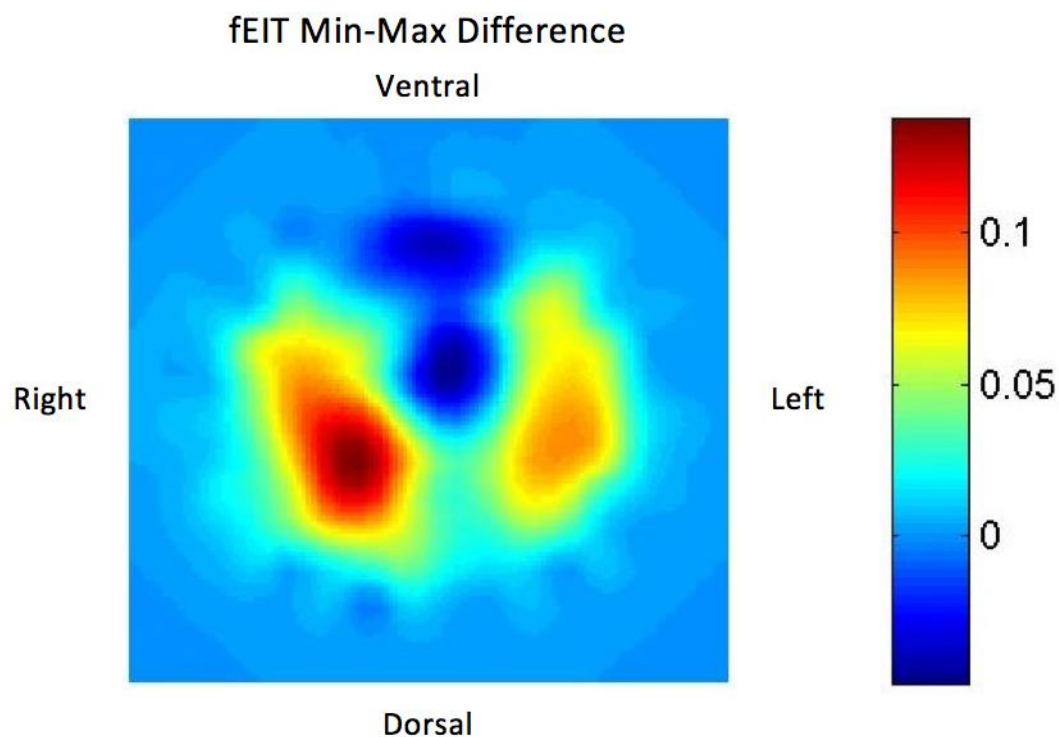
The fEIT image generated from a healthy boy (1.29 years old) in the supine position (head midline). The orientation is similar to that of a CT scan. Red areas indicate regions of high relative impedance change and blue areas indicate regions of low relative impedance change.
